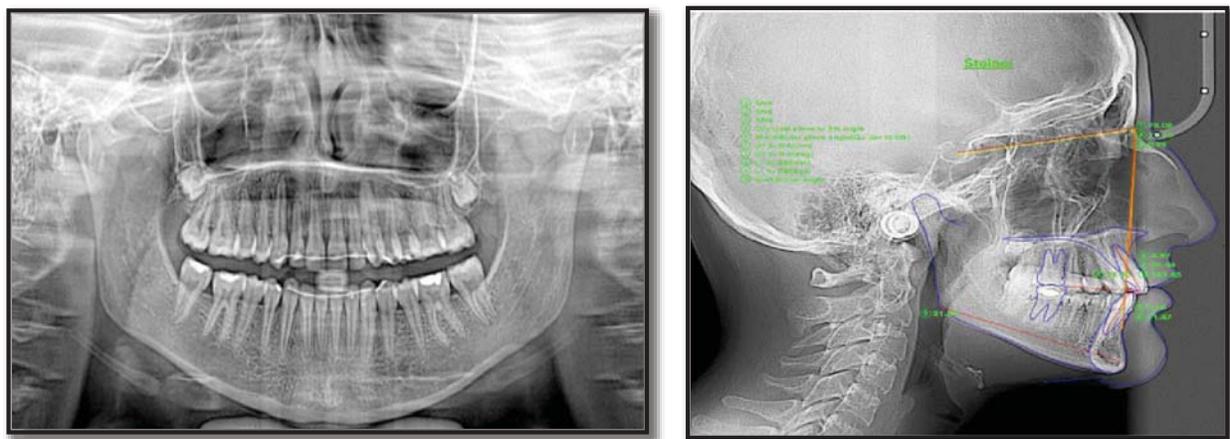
Treatment progress using: (a) Intraoral images with OPG and cephalometric radiography; (b) quad-helix appliance; (c) (UDEX) appliance progression; (d) final result and permanent and VFR retainer
